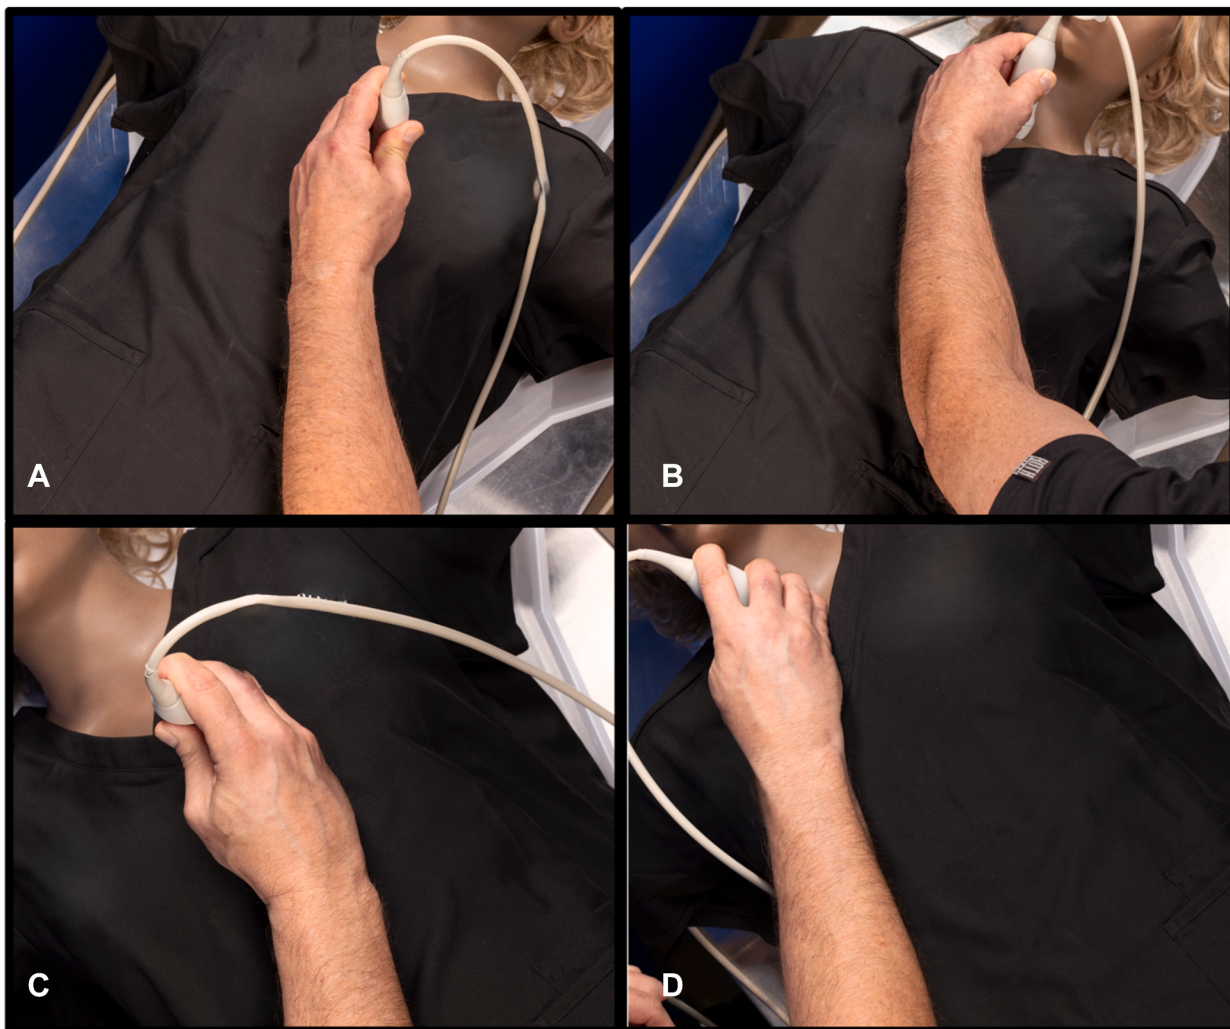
Probe grip and positioning are demonstrated for both left-handed and right-handed scanning in the parasternal and suprasternal notch imaging windows. Left-handed probe grips are shown for the parasternal (A) and suprasternal notch (B) views; right-handed probe grips are shown for the parasternal (C) and suprasternal notch (D) views. In both imaging windows, sonographers generally maintain the standard grip, with only minor wrist or probe orientation adjustments as needed based on scanning position and patient anatomy.
